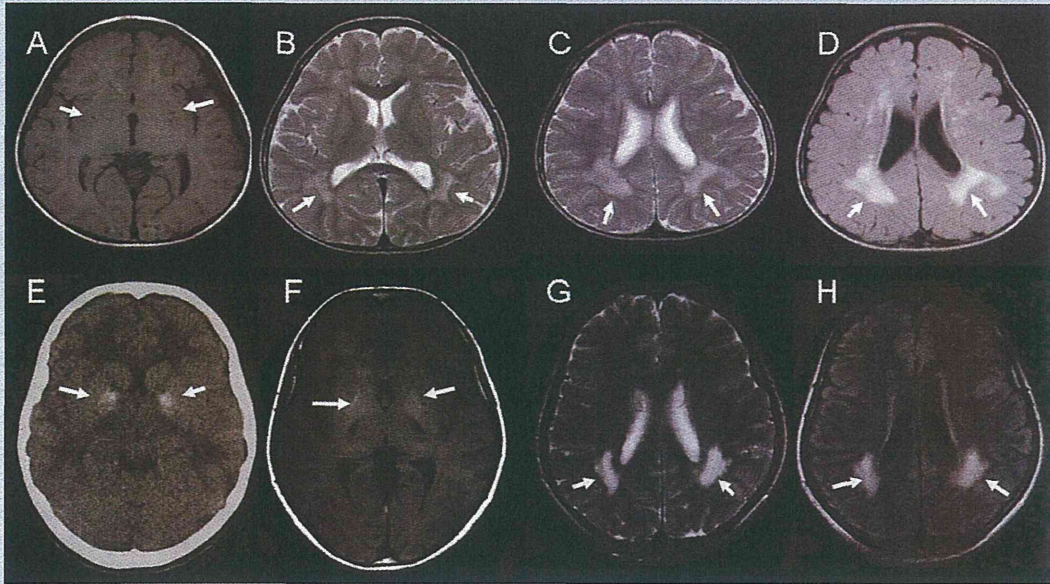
Images of the brain radiological examinations. A–D: Axial images of brain MRI examined when Patient 1 was 26 months old. A: T1-weighted image indicates low-intensity areas in the basal nucleus, indicating dilated Virchow–Robin spaces (arrows). T2-weighted (B,C) and FLAIR (D) images indicate abundant high-intensity areas in the white matter (arrows). E: Cranial CT image examined when Patient 2 was 12 years old shows the finding of calcifications in the basal nucleus (arrows). F–H: Axial images of brain MRI examined when Patient 2 was 14 years old. F: T1-weighted image indicates high-intensity areas in the basal nucleus (arrows). T2-weighted (G) and FLAIR (H) images indicate occipital-dominant high-intensity areas in the white matter (arrows).
